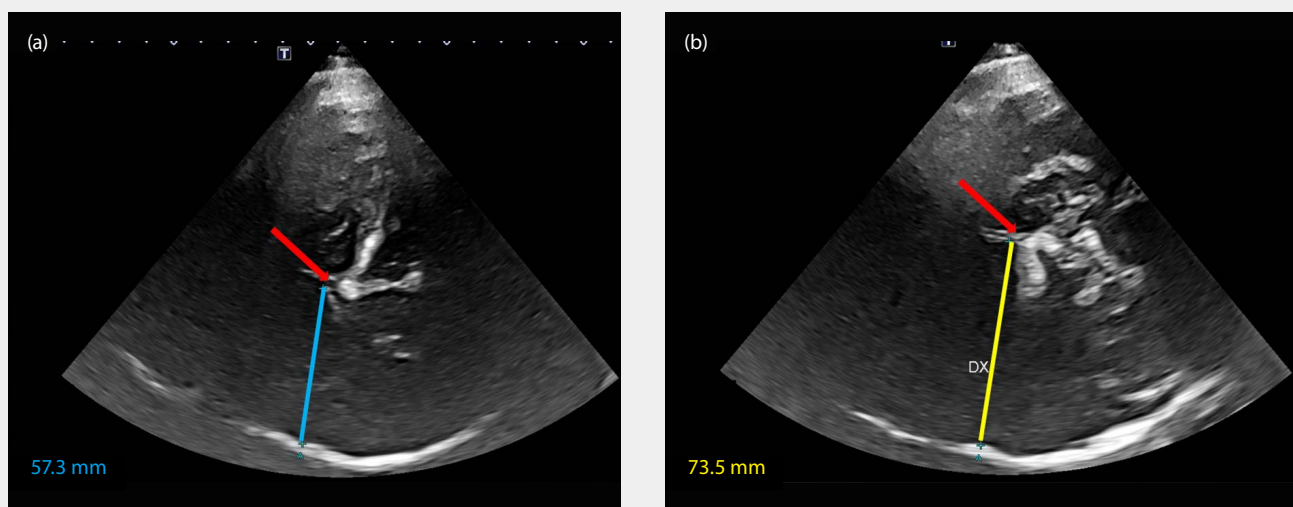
Ultrasound application conclusion in the clinic: This patient's work-up was conservative so ultrasound can monitor morphological changes. (a) Insonation through right temporal window to measure left hemisphere. (b) Insonation through left temporal window to measure right hemisphere.
